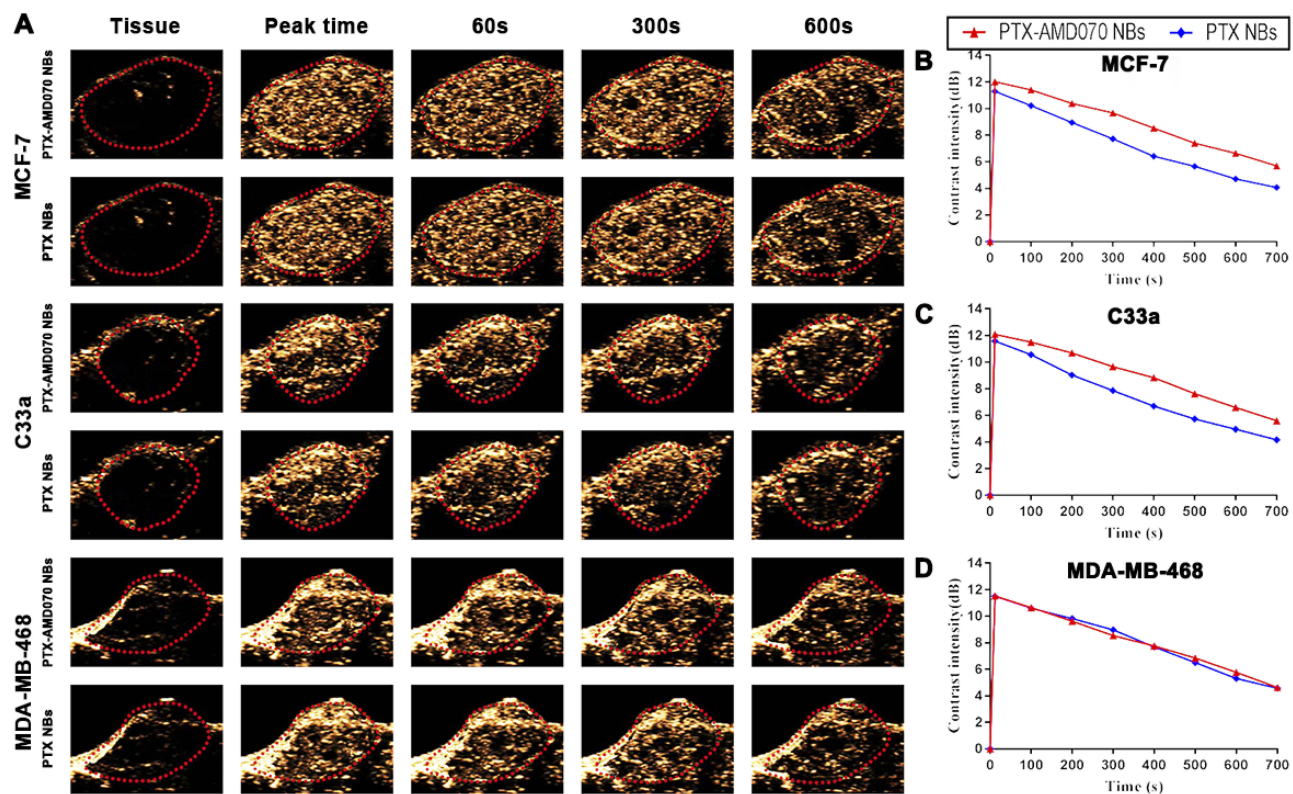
Ultrasound images of nanobubbles in xenografts. (A) Ultrasound images of nanobubbles in the three types of xenografts. The red dotted circle represents the xenograft area. (B–D) The time-intensity curves of the nanobubbles in the MCF-7, C33a, and MDA-MB-468 xenografts.
